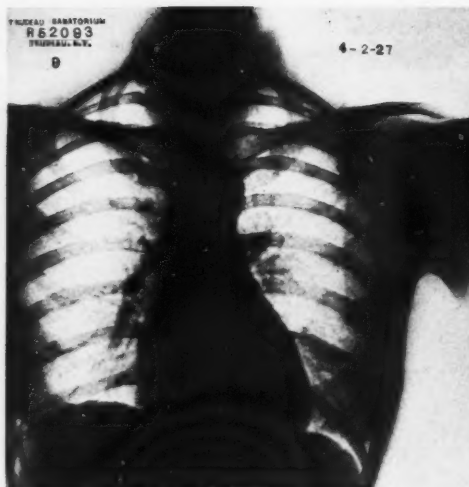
Physical signs more than x-ray findings: bacilli negative. Physical signs: left lung, moderately coarse râles throughout. X-ray findings: left lung, small amount of infiltration to second lobe on the right.
